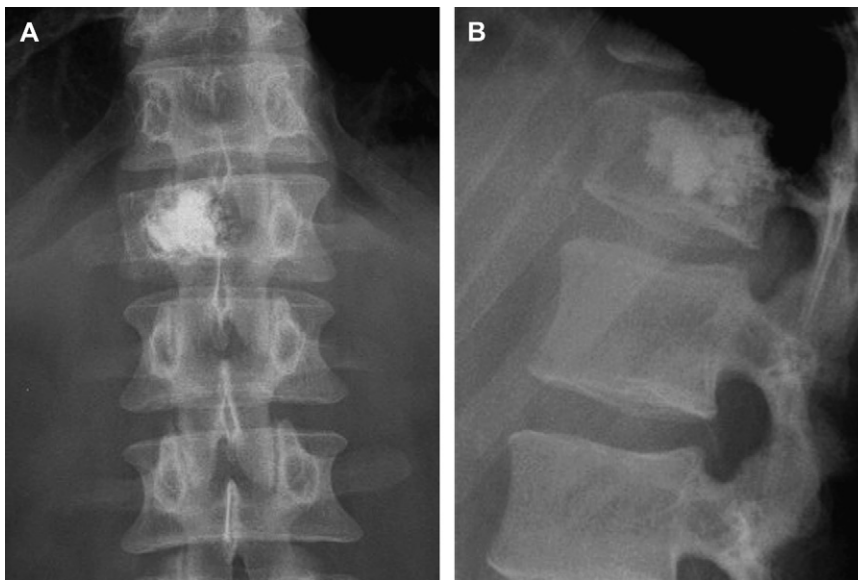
Anteroposterior (A) and lateral (B) radiographs show the PMMA within the right L1 vertebral body status after vertebroplasty/kyphoplasty. There is an associated mild compression fracture of the right L1 vertebral body.
